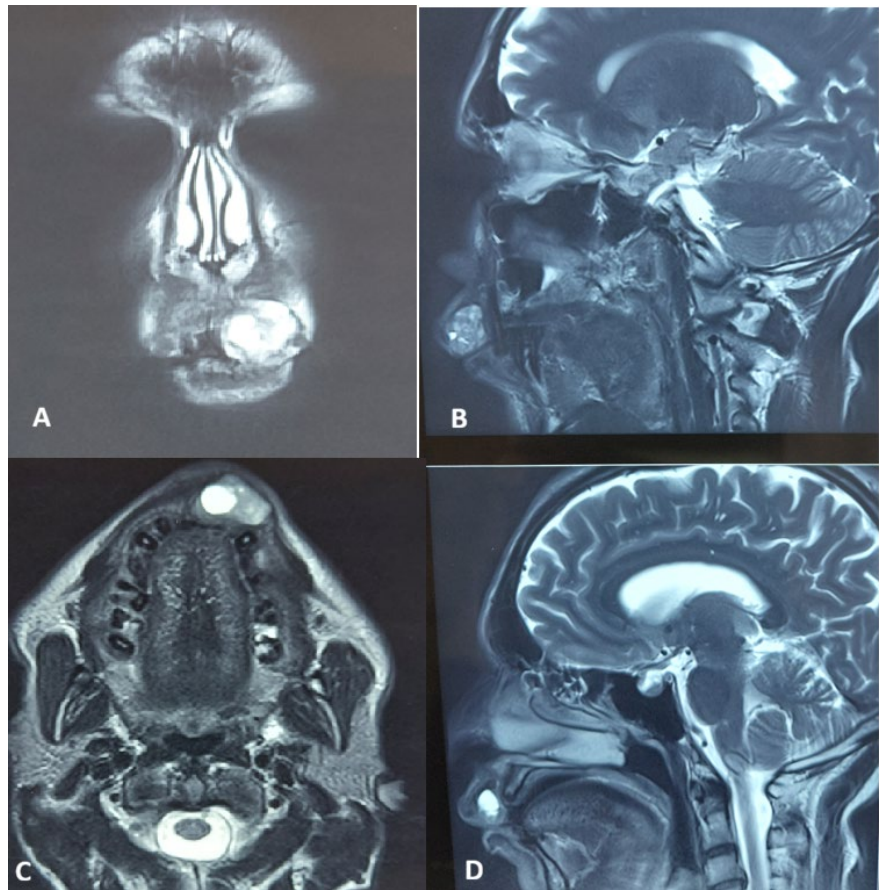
Magnetic resonance imaging (MRI) of the upper lip lesion. (A) Coronal T2-weighted image demonstrating a well-circumscribed, oval lesion arising from the left upper lip. ((B), (D)) Sagittal T2-weighted images showing a submucosal, encapsulated mass with predominantly hyperintense signal intensity and well-defined margins, without evidence of infiltration into adjacent structures. (C) Axial T2-weighted image confirming the lesion's well-demarcated borders and homogeneous to mildly heterogeneous high signal intensity.
